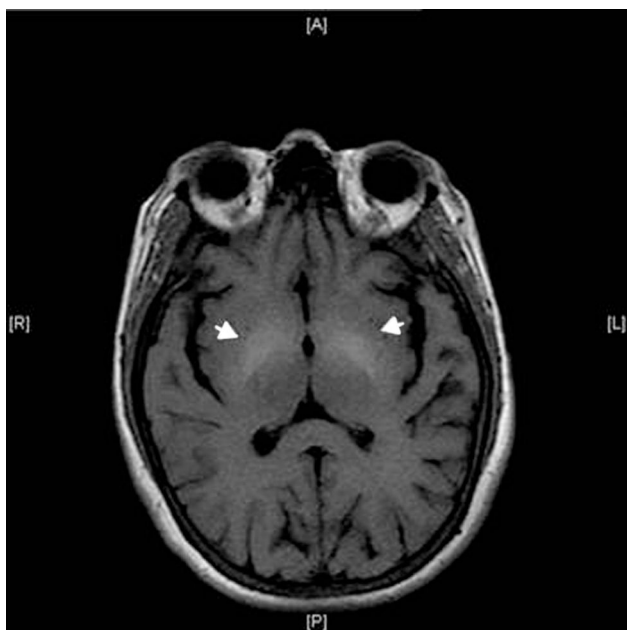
Axial T1-weighted brain magnetic resonance imaging. Symmetrical hyperintensities in lentiform nuclei (arrows).
